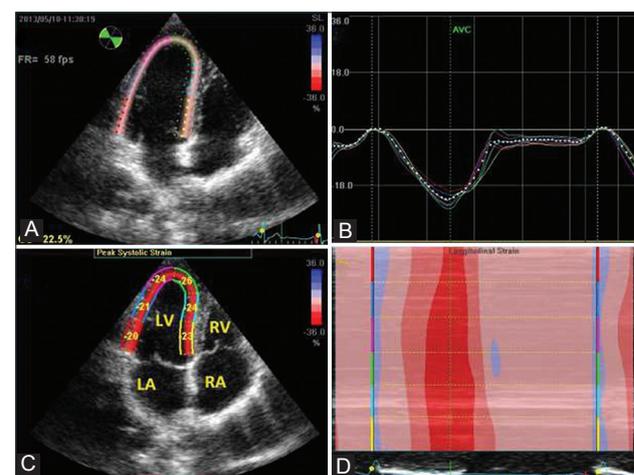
Longitudinal strain in an apical four chamber view. A and B show peak systolic strain in colour. C: display average segmental strain in graphs, D: shows peak systolic strain with M-mode
